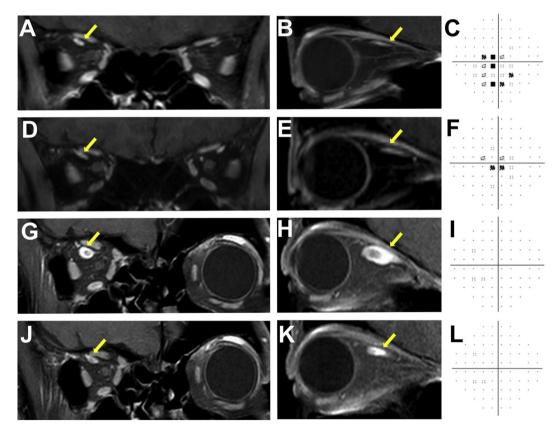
Temporal changes of right superior ophthalmic vein findings on Gd-enhanced magnetic resonance imaging and Humphrey visual field test. Enlargement of the right superior ophthalmic vein (SOV) (arrow) and Gd enhancement improved after two courses of steroid pulse therapy (A and B), but the central scotoma remained (C). Magnetic resonance imaging (MRI) findings (D and E) (arrow) and visual field (VF) test (F) show further improvement after the third course of steroid therapy. One month after warfarin potassium discontinuation, MRI showed recurrence of vasculitis in the right SOV with a large thrombus formation (G and H) (arrow), but the VF test kept improving (I). The latest MRI showed mildly enlarged right SOV with a smaller thrombus in the middle of the vein and a less enhanced wall (J, K) (arrow) without visual field disturbance (L). A, D, G, and J: Gd-enhanced coronal MRI. B, E, H, and K: the sagittal section of orbital MRI. C, G, I, and L: the pattern deviation of Humphrey field analysis.
